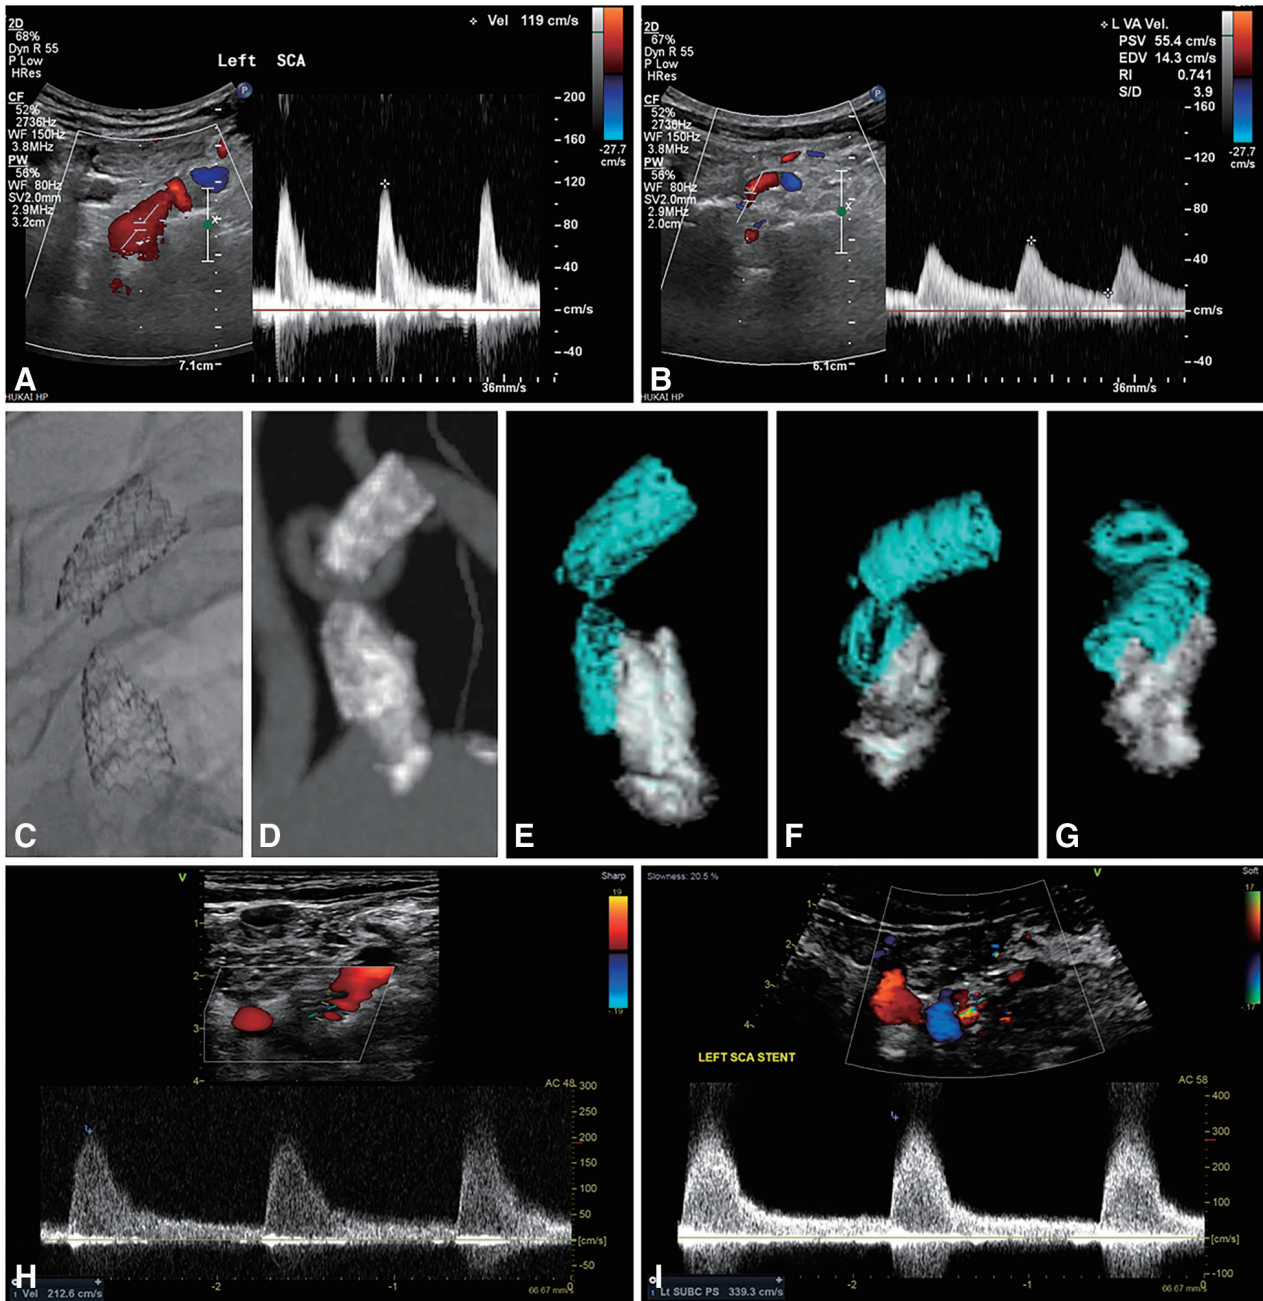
Follow-up Doppler ultrasound the day after initial PTAS shows a normal PSV (A) and antegrade flow of the VA (B). Imaging 30 days after PTAS on fluoroscopy (C) and CTA on the maximum intensity projection image (D) show a stent fracture at the mid-portion. CTA of the volume rendering images shows a crushed and twisted stent with severe calcification (E: posterior-anterior view, F: cranial view, G: caudal view). Follow-up Doppler ultrasound 3 months (H) and 9 months (I) after PTAS shows progressively increased PSV at the fractured stent (212.6–339.3 cm/s). CTA: computed tomography angiography; PSV: peak systolic velocity; PTAS: percutaneous transluminal angioplasty and stenting; VA: vertebral artery
